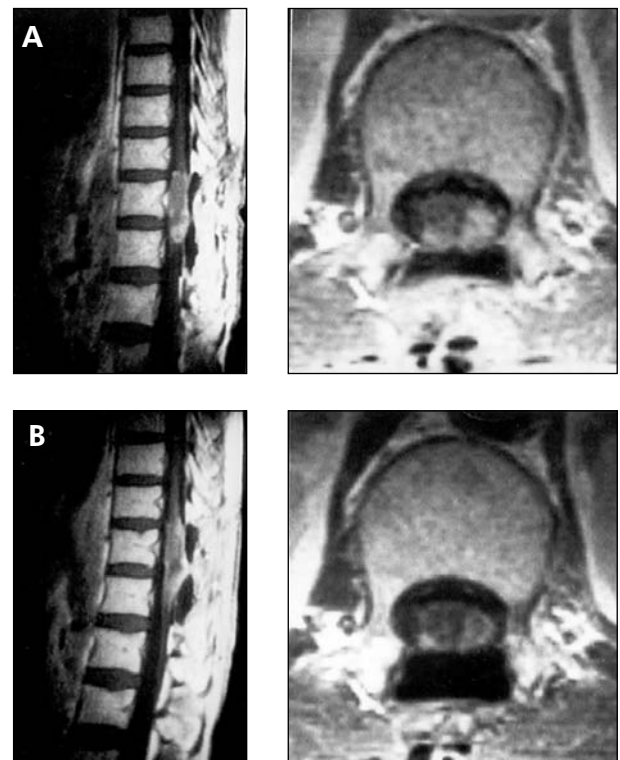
Contrast-enhanced sagittal and horizontal T1 magnetic resonance imaging scans. A The residual intramedullary glioblastoma after operation, B regression of tumour after radio- and chemotherapy
